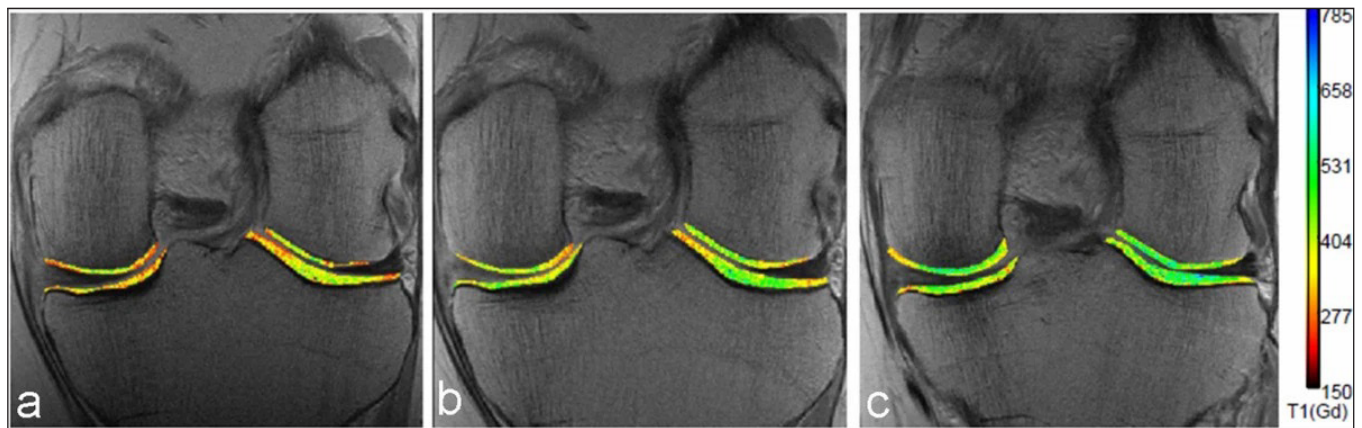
dGEMRIC, magnetic resonance imaging of the knee joints, contrasting with Gd-DTPA²⁻. (a) Before, (b) 3 months, and (c) 1 year after meniscal repair surgery. These images demonstrate the potential to show changes in the molecular state of articular cartilage. dGEMRIC provides the ability to monitor the recovery of articular cartilage after injury or intervention aimed at improving the biomechanical condition of the joint [19]
